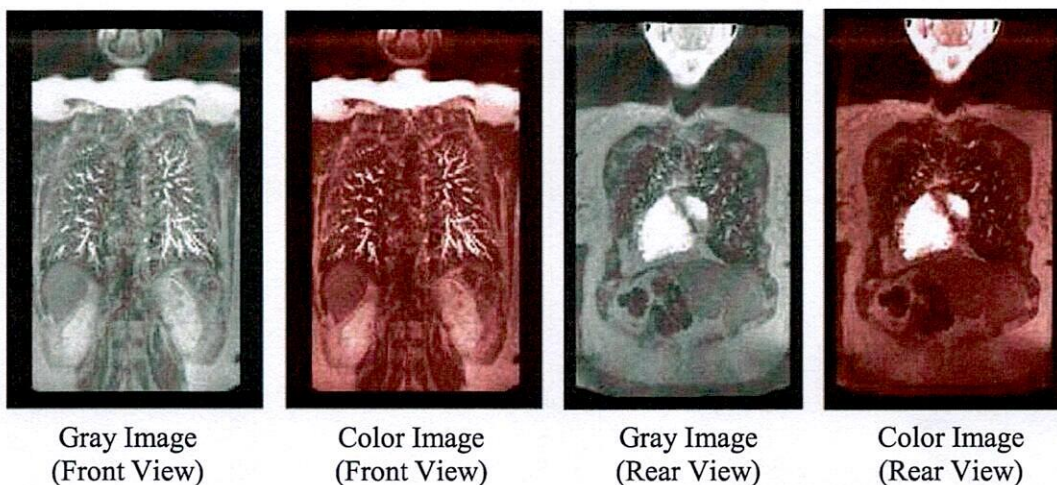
MR image cetautomatix and different views
